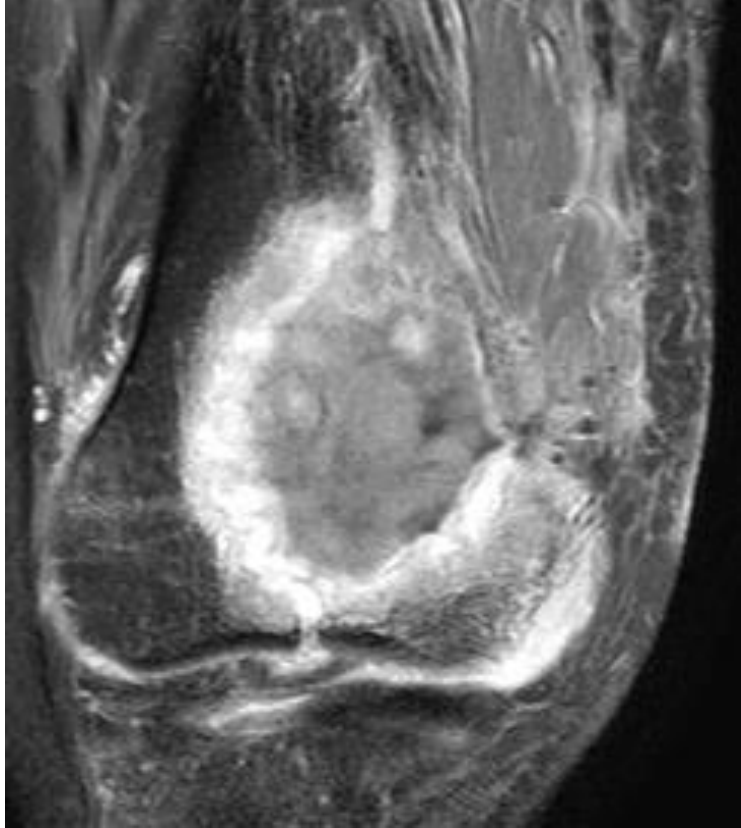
MRI Image of Aggressive Giant Cell Tumour of Distal Femur showing articular and soft tissue extension.
